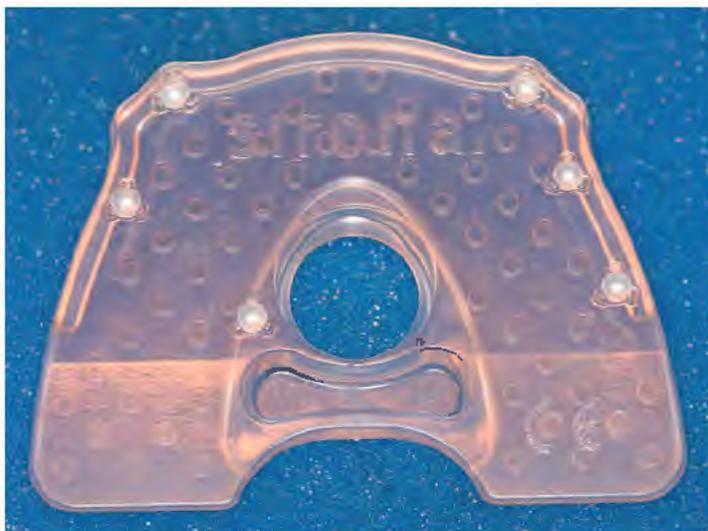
Galileos radiographic bite plate with spherical fiduciary radiopaque markers.
